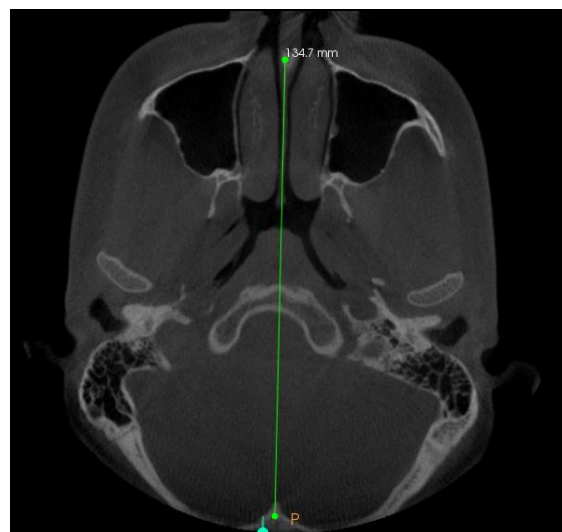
Method of Standard Orientation and Reference Line in Axial View of CBCT Scan
